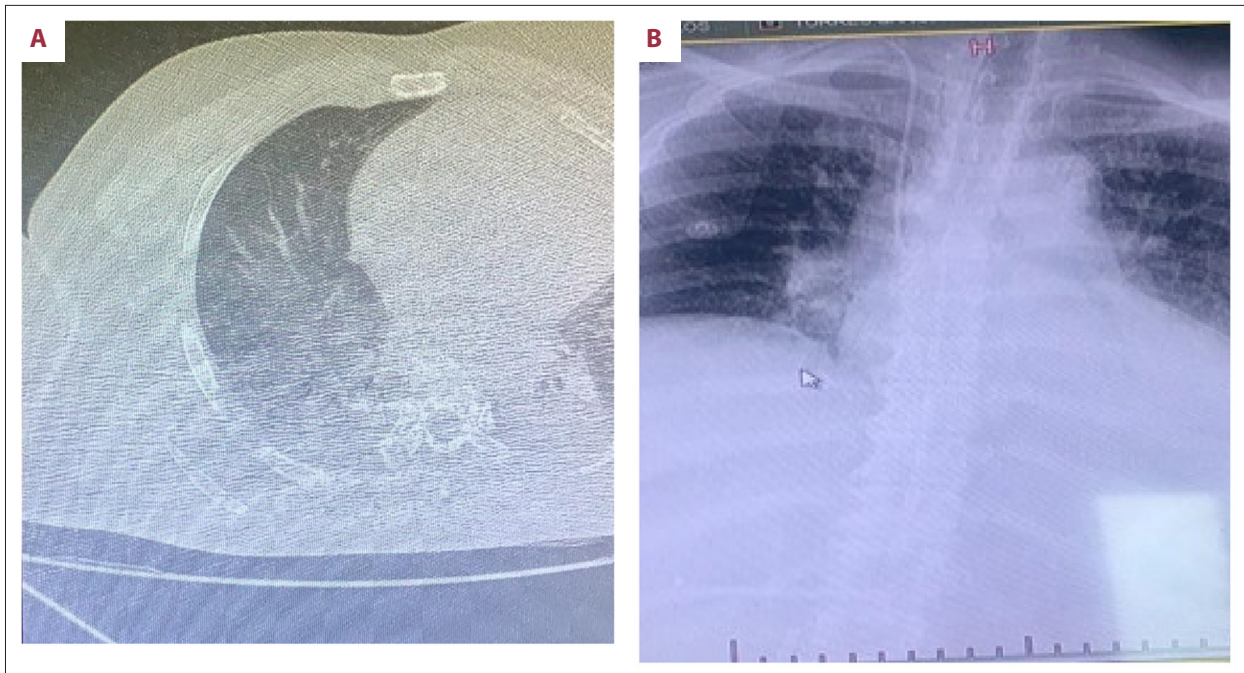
(A) Chest X-ray shows infiltrate of the right hilum and (B) shows opacity in both lung bases.
